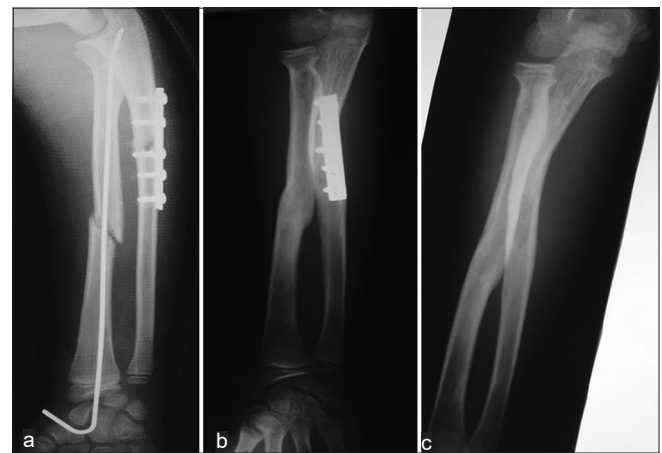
(a) Postoperative radiograph showing fixation of all fractures. (b) Eight weeks postoperative following removal of the K-wire. (c) Six months postoperative following removal of the plate showing sound union of all fractures, with well-located radial head.
